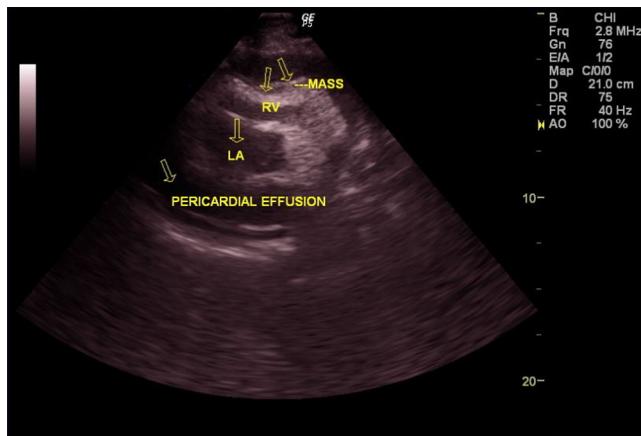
Echocardiography showing tumour over myocardial surface.
